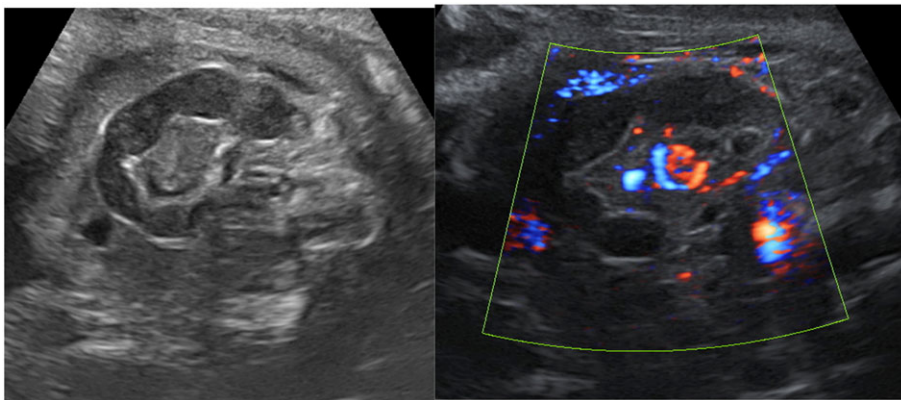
Case #10, 32 weeks of gestation. Prenatal midgut volvulus: Ultrasound features: whirlpool sign (axial ultrasound image in 2D and color Doppler). With color Doppler, mesenteric vessels appeared as a vascular pellet at the center of the spiraled intestinal loops [Colour figure can be viewed at wileyonlinelibrary.com]
